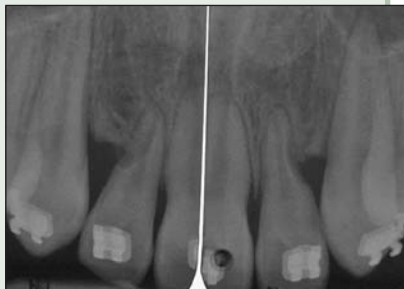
Periapical radiographs obtained after treatment demonstrate damage to the roots of the lateral incisor.
